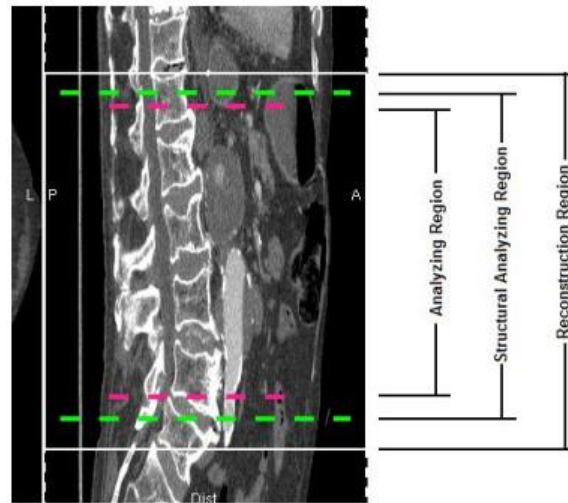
Importing DICOM images from a CTA scan of a patient with an AAA
